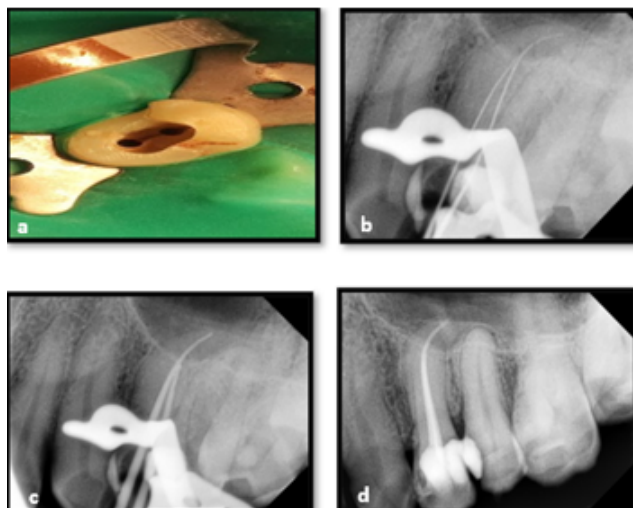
a:) Intraoral photograph of access opening, b:) Working length radiograph, c:) Master cone radiograph, d:) Post obturation radiograph.
